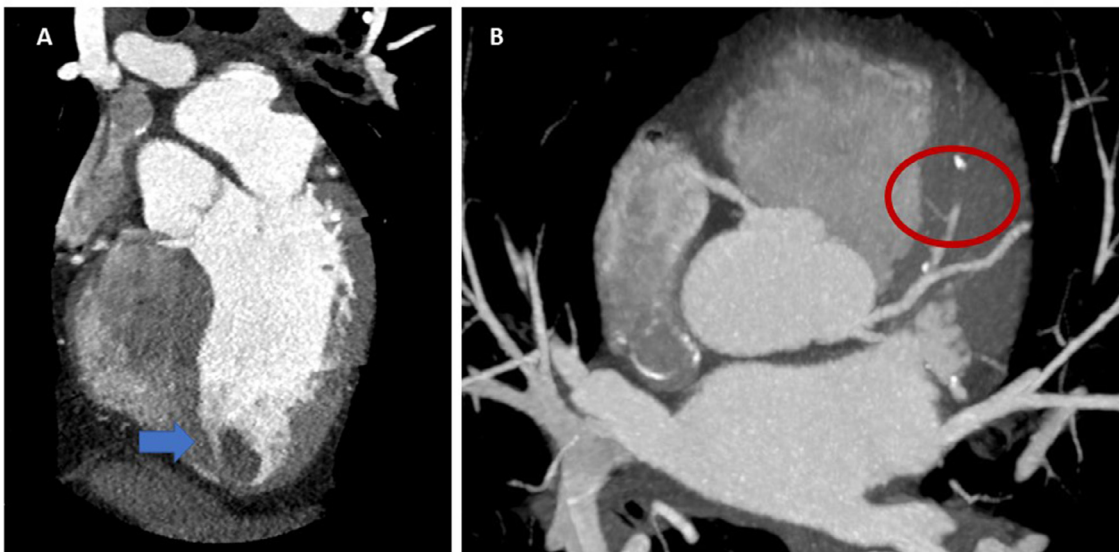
Case 3 (A) Cardiac CT, 3D MPR reconstruction showing the evidence of apical thrombus (blue arrow); (B) Cardiac CT, axial plane with maximum intensity projection (MIP); subocclusive type opacification defect of the middle segment of the DA (red circle).
